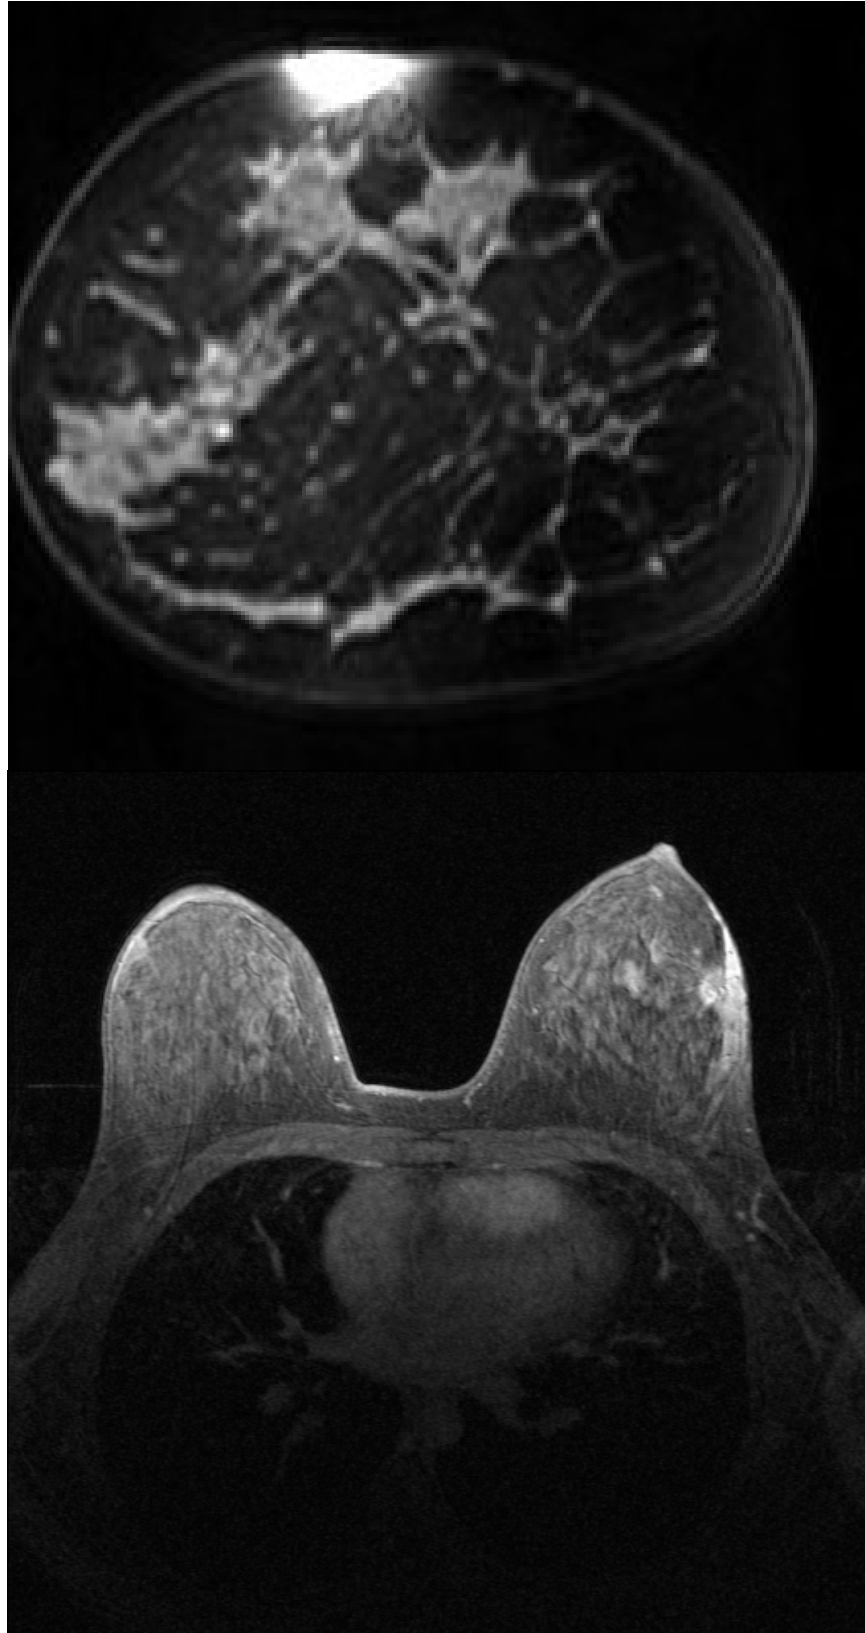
Coronal (Top) and transverse (Bottom) breast MRI images.
